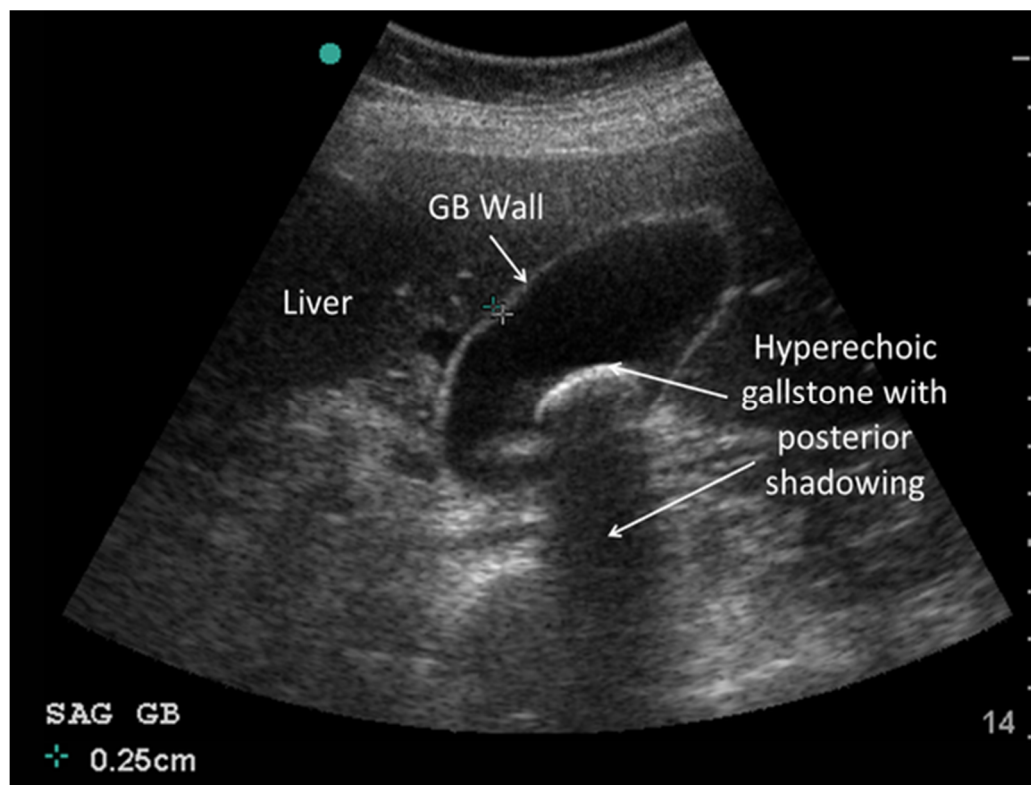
Ultrasonography
